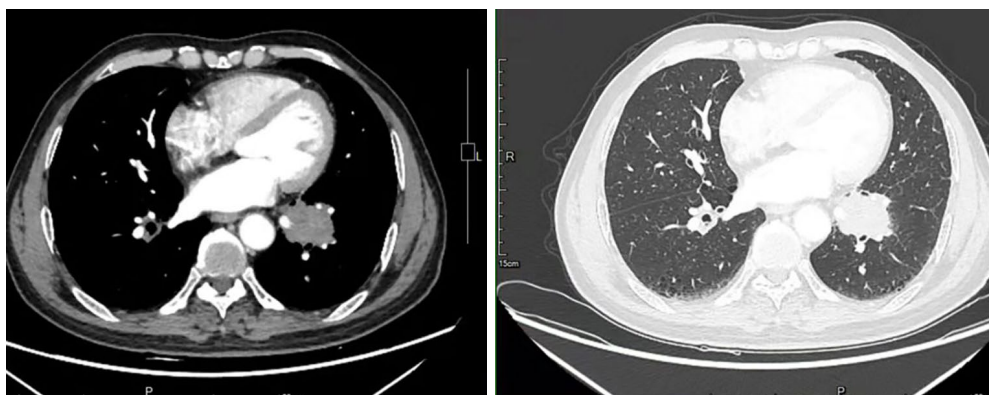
CT of baseline. CT, computed tomography.
